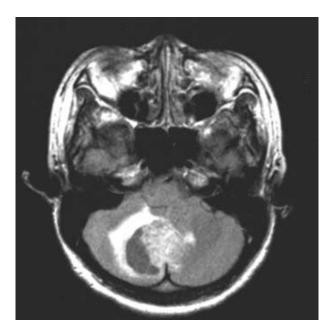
Brain MRI shows a mass lesion having a solid and cystic component with a surrounding edema in the midline of the cerebellar hemisphere near the fourth ventricle.
